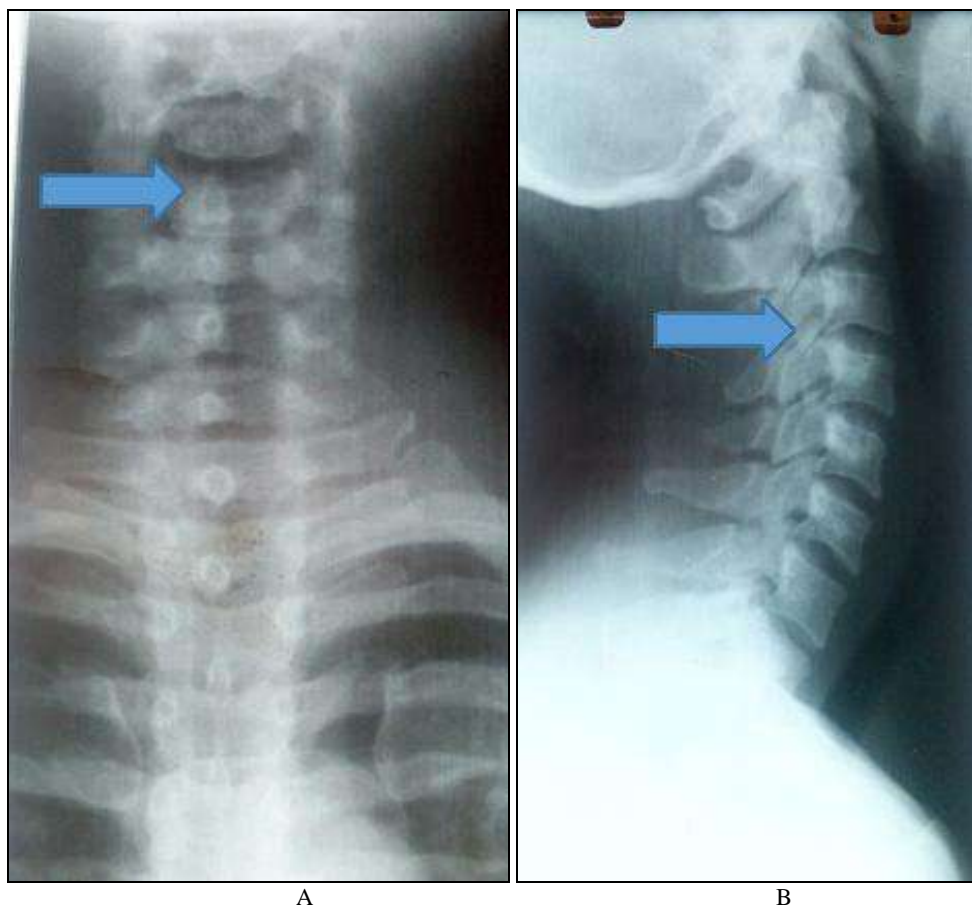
A and B: X-ray images show incipient cervicarthrosis (see posterior wall) and slight anterior tracheal compression
